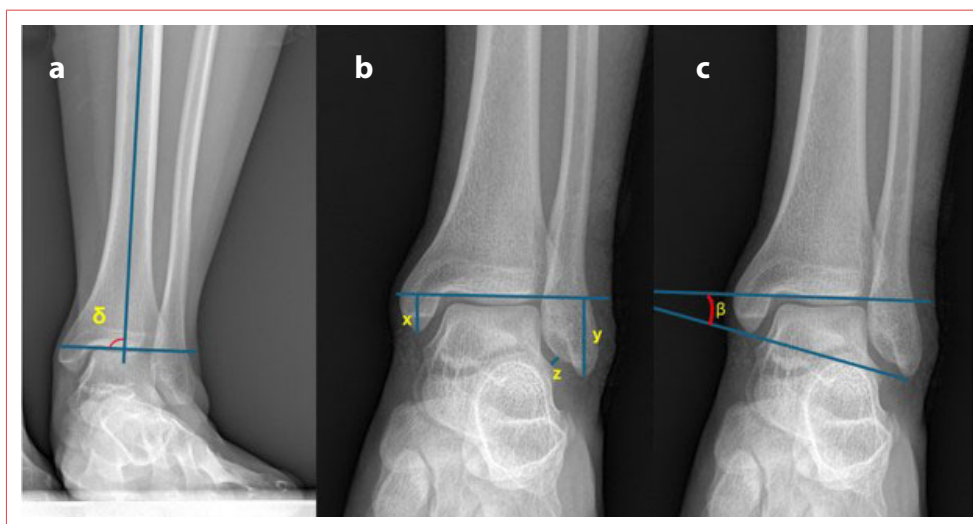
Radiographic measurements on the mortise ankle radiograph. (a) Measurement of the distal tibial lateral angle (DTLA), with δ representing the angle between the longitudinal axis of the distal tibial shaft and the tibial plafond line. (b) Measurement of medial malleolar length (x, MML), lateral malleolar length (y, LML), and talar dome–distal fibula distance (z, TD-FD). The lateral-to-medial malleolar length ratio (LMMLR) was calculated as y/x . (c) Measurement of the talocrural angle (TCA), with β representing the angle between the tibial plafond line and the line connecting the tips of the medial and lateral malleoli.
